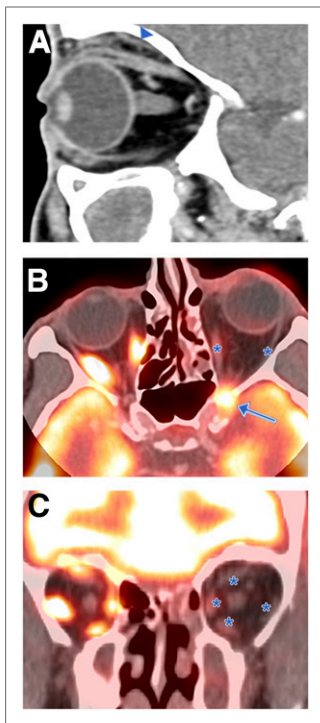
CNs V1, II, III, IV, and VI involvement in patient with basal cell carcinoma of left eyebrow after resection, now presenting with progressive loss of left vision and inability to move left eye. Sagittal CT (A), axial ^{18}F -FDG PET/CT (B), and coronal fused PET/CT (C) images of left orbit show cord of soft tissue in superior extraconal space tracking along course of left CN V1 (arrowhead) extending into left orbital apex. Hypermetabolic soft-tissue mass in left orbital apex (arrow) involves CNs II, III, IV, and VI, resulting in vision loss and denervation of left orbital extraocular muscles with atrophy and decreased ^{18}F -FDG uptake in extraocular muscles (asterisks). Further surgical treatment was not pursued, as PNS would have required craniectomy and orbital exenteration.
